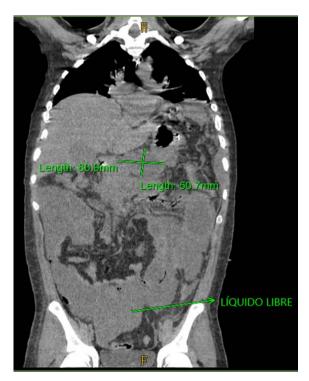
Simple coronal cut CT scan of the abdomen with evidence of a pancreatic pseudocyst measuring $80.99 \text{ mm} \times 50.7 \text{ mm}$ with free fluid in the abdominal and pelvic cavity.
